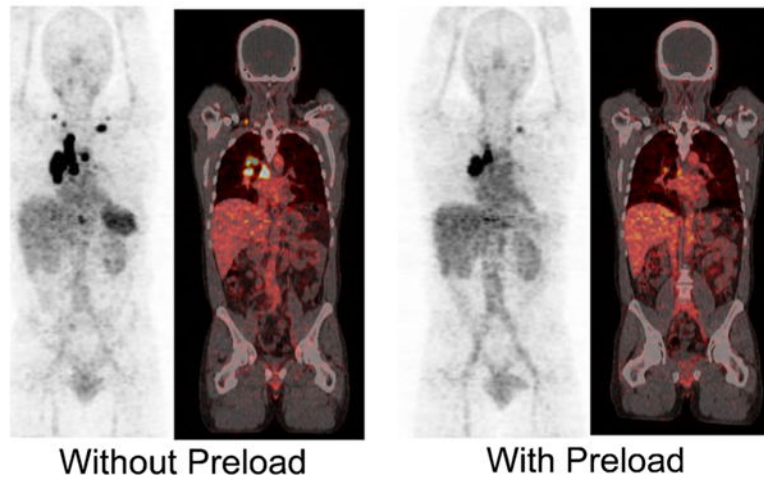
Biodistribution of ^{89}Zr -rituximab in an adult male with B cell-depleted grade II follicular lymphoma. PET/CT imaging was performed 6 days after injection of ^{89}Zr -Rituximab with or without a preload of unlabeled rituximab. Tumor targeting is higher without a preload of unlabeled rituximab. Reprinted with permission [119]
